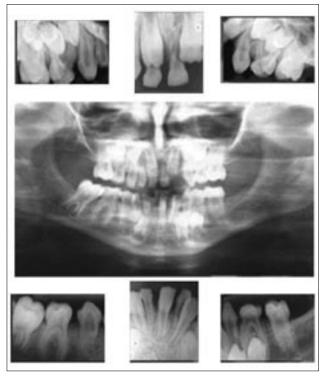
Panoramic and dental roentgenograms view showing multiple missing teeth in a patient with incontinentia pigmenti.
